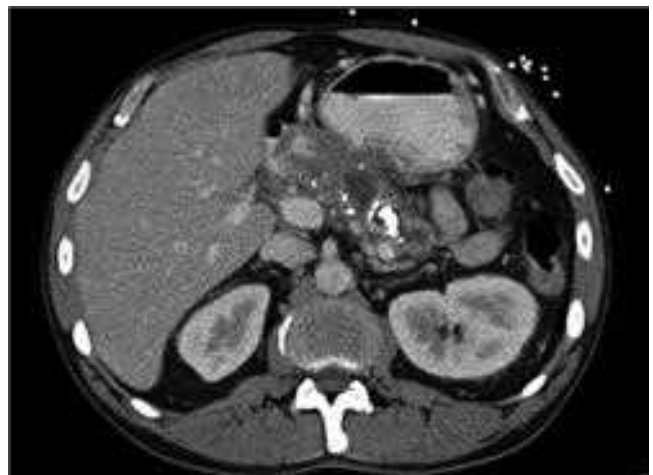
Computed tomographic imaging of chronic pancreatitis. A dilated pancreatic duct is seen, with evidence of intraductal stones and parenchymal calcification. (Reproduced with permission from Forsmark CE.²⁰¹ *Management of pancreatitis.* *Gastroenterol.* 2013;144:1282. © 2013 AGA Institute. Published by Elsevier, Inc. All rights reserved.)
